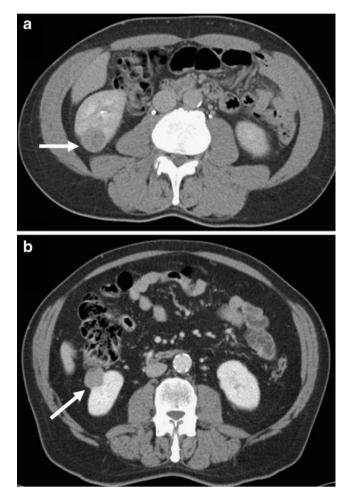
Surgical approach. Preoperative CT scans are shown for two tumors. a CT scan of a posteriorly located tumor selected to undergo percutaneous RFA because of its posterior location and percutaneous accessibility. b CT scan of an anteriorly located tumor in close proximity to bowel is shown. This is an example of a tumor selected for laparoscopic RFA because of its anterior location and adjacent organs. *CT* computed tomography, *RFA* radiofrequency ablation
